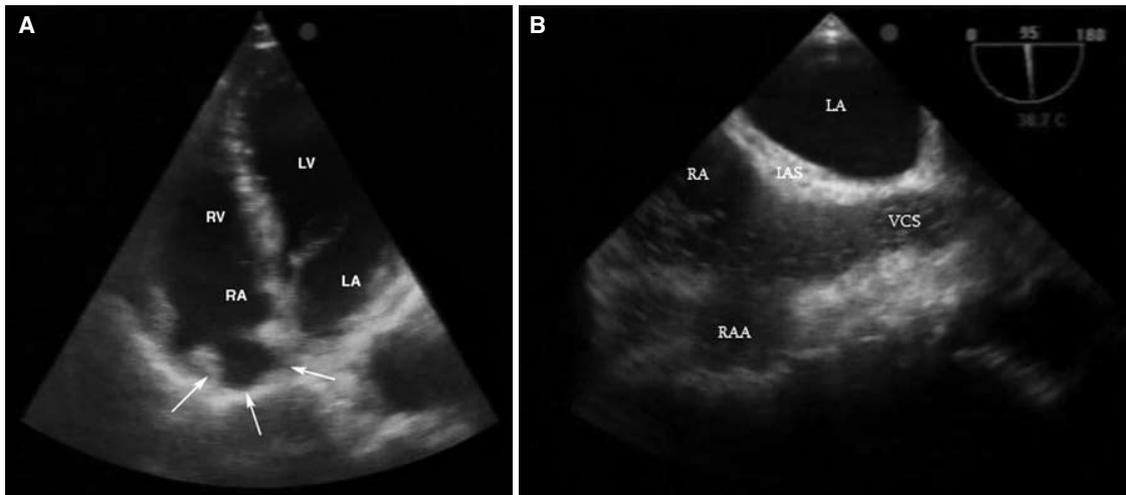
(A) Transthoracic echocardiography from the apical four-chamber view demonstrating an aneurysmal structure related to the right atrium (arrows). (B) Transesophageal echocardiography showing a right atrial appendage aneurysm and atrial structures. LA: Left atrium; LV: Left ventricle; RA: Right atrium; RV: Right ventricle; RAA: Right atrial appendage aneurysm; IAS: Interatrial septum; VCS: Vena cava superior.
